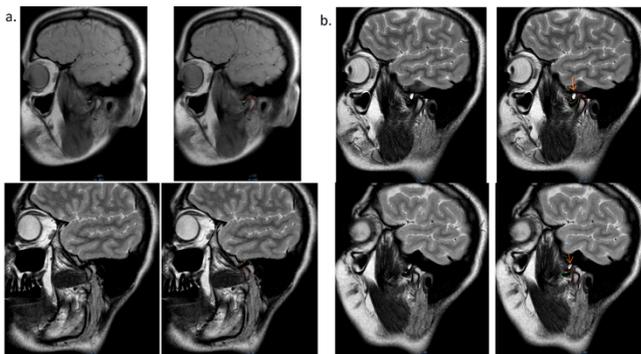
The MRI of the TMJ at the end of splint therapy. The arrow indicates the area of interest. a. Right TMJ. b. Left TMJ.
